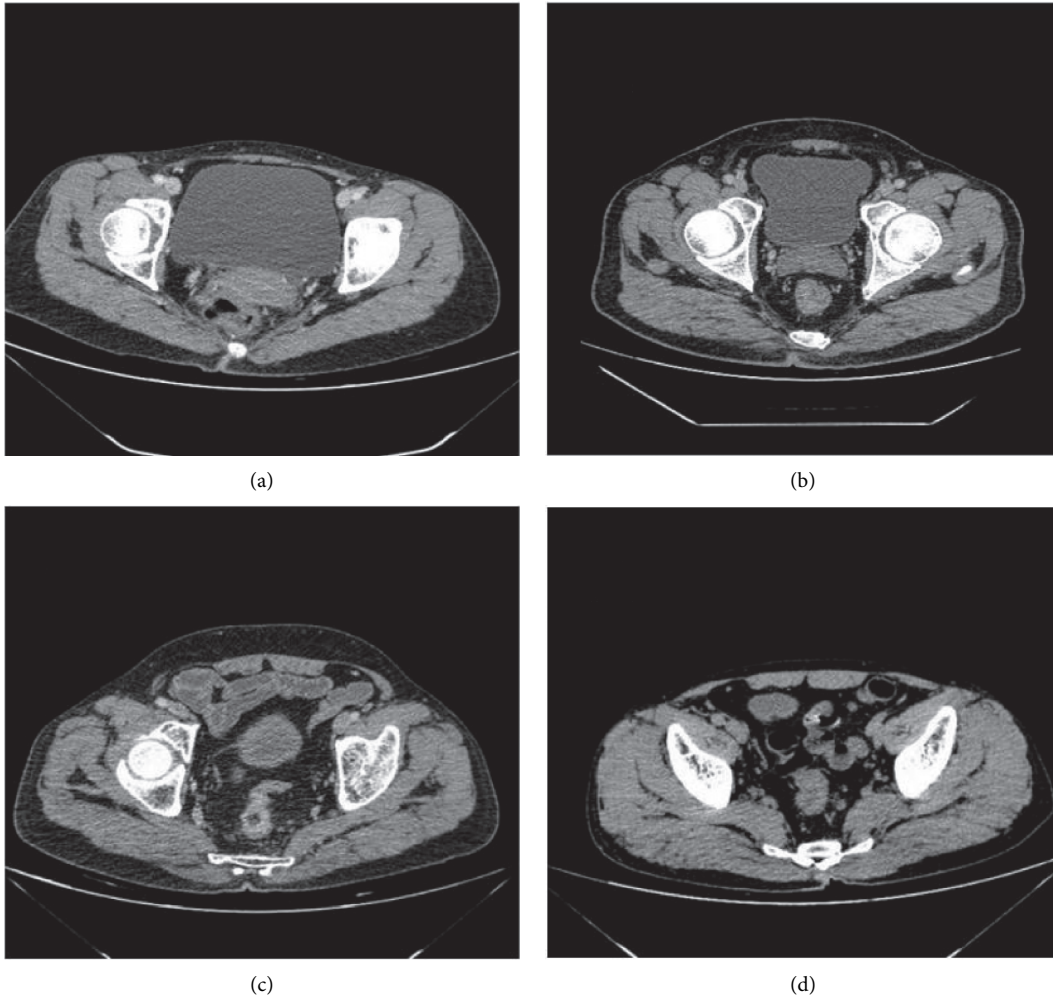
Enhanced CT image of patients with RC. (a) A 55-year-old woman in stage T1 RC presented with slight enhancement in submucosal lesions. (b) A 49-year-old man in stage T3 RC with involvement of the muscularis propria and perirectal tissues. (c) A 61-year-old female patient in stage N1 RC had subserosal invasion and lymph node metastasis. (d) A 37-year-old woman in stage N2 RC with invasion to the muscularis propria and lymph node metastasis.
